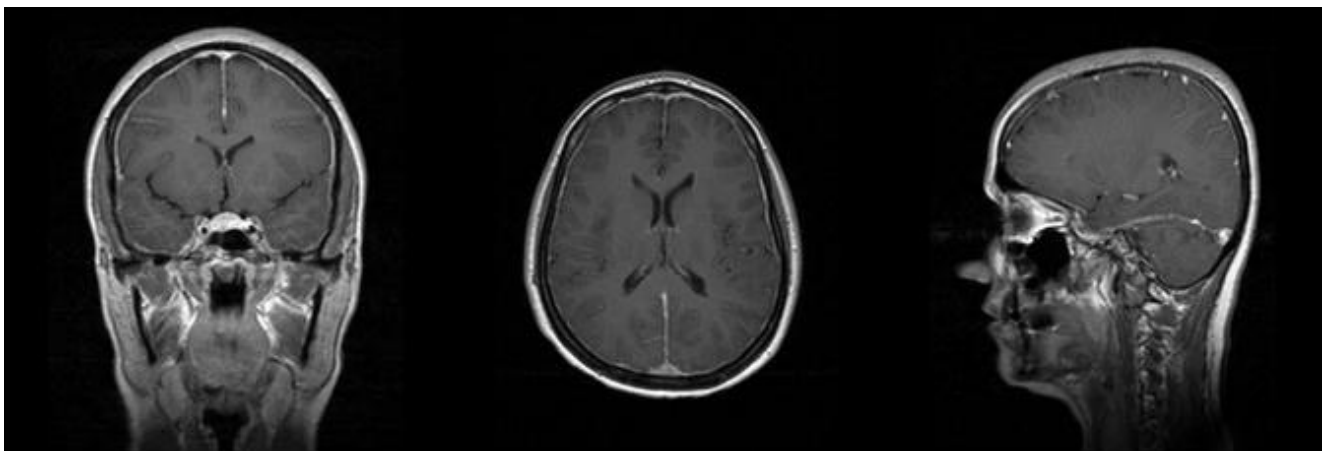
Diffuse pachymeningeal enhancement in the patients' brain MRI
